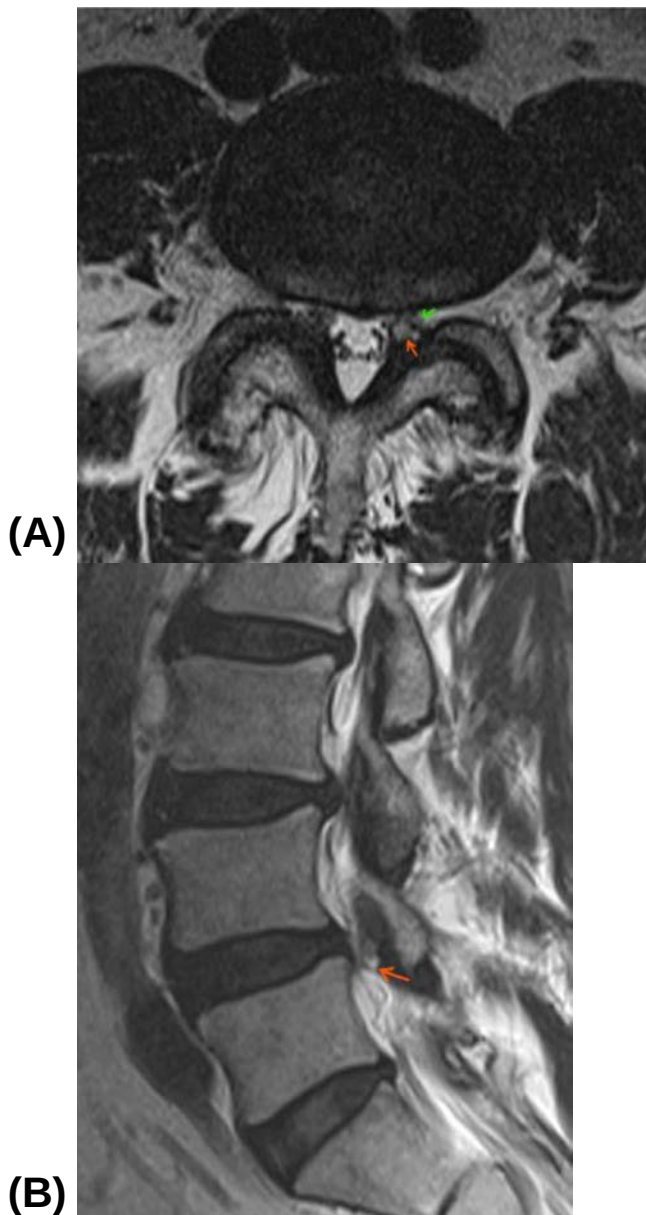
Magnetic Resonance Imaging of the Lumbar Spine showing L4/5 Facet Joint Cysts compressing on the Left L5 traversing Nerve Root in both (A) Axial, and (B) Sagittal Views. *Red arrows indicate the facet cyst, and the green arrow is pointing at the compressed left L5 traversing nerve root.
